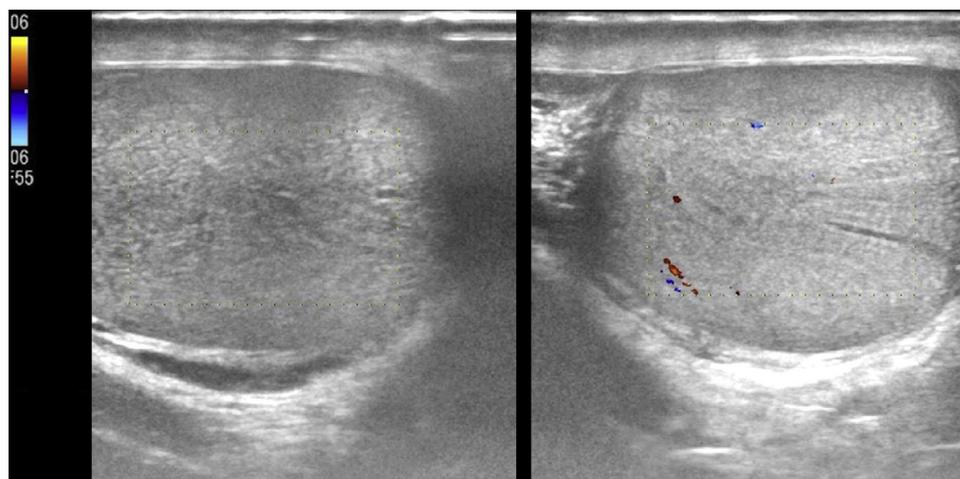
Scrotal ultrasonography of the bilateral testes, demonstrating normal color flow in the right testicle (left panel) compared with absence of color flow in the left testicle (right panel).
